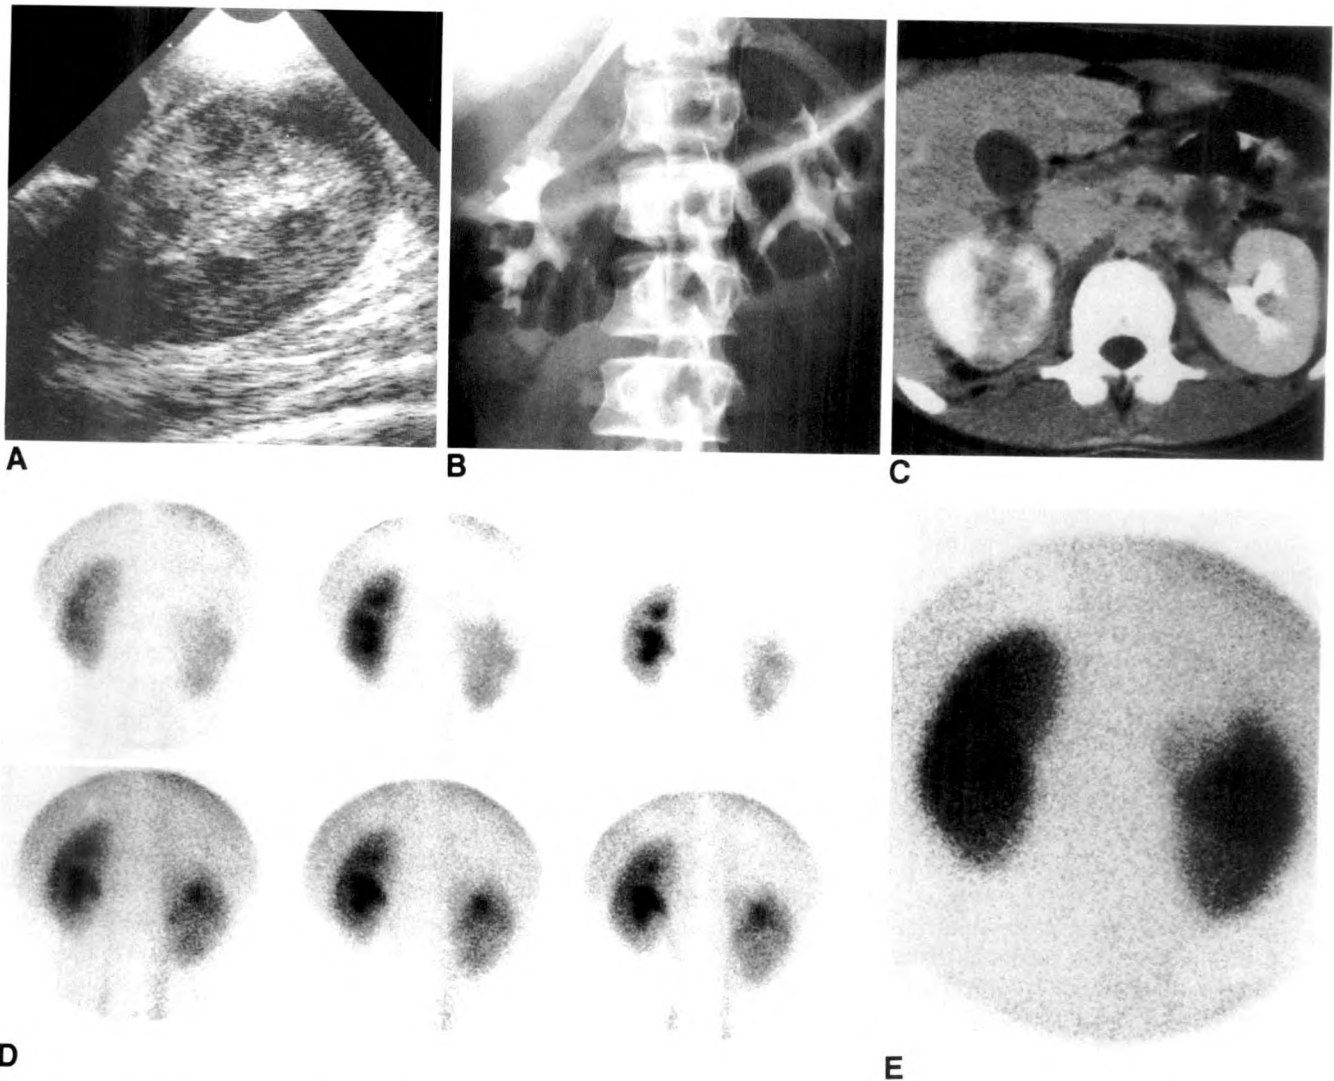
A, Longitudinal sonogram of right kidney of 16-year-old girl with sepsis and right flank pain shows generalized enlargement of kidney with surrounding perinephric fluid. There are scattered areas of decreased echogenicity.
